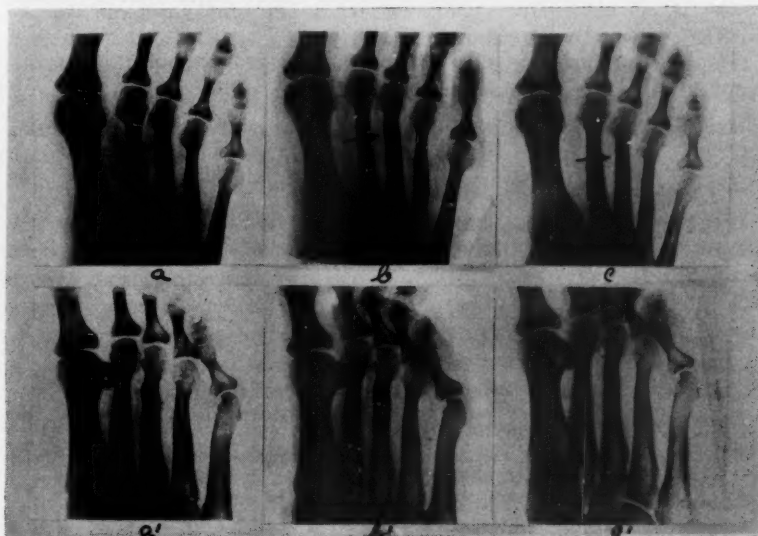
a, Roentgenogram 43 days after onset of symptoms; anteroposterior view; note dense spindle-shaped callus. a', oblique view. b, Roentgenogram three months later; anteroposterior view; note hard callus almost tubular in shape. b', oblique view. c, Roentgenogram eleven months after onset; anteroposterior view; note only a little thickening of the cortex at site of fracture. c', oblique view.
